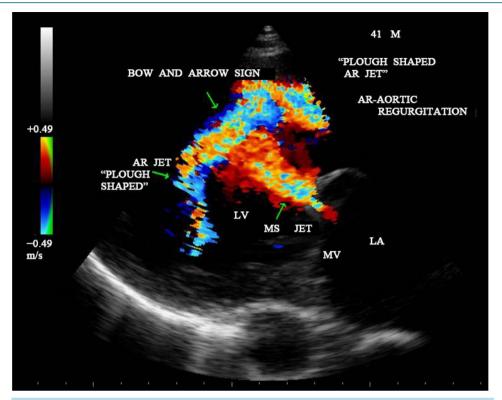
CW doppler showing the MS and AR jets-"bow and arrow sign" in parasternal long axis view—"plough" shaped AR jet.
